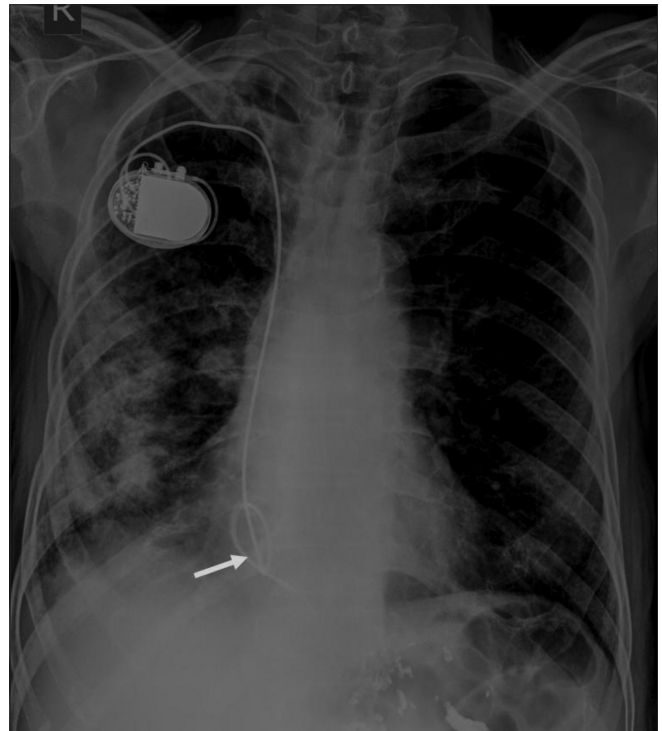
Frontal chest radiograph shows coiling of the lead (arrow) of a single-lead pacemaker in the right atrium
